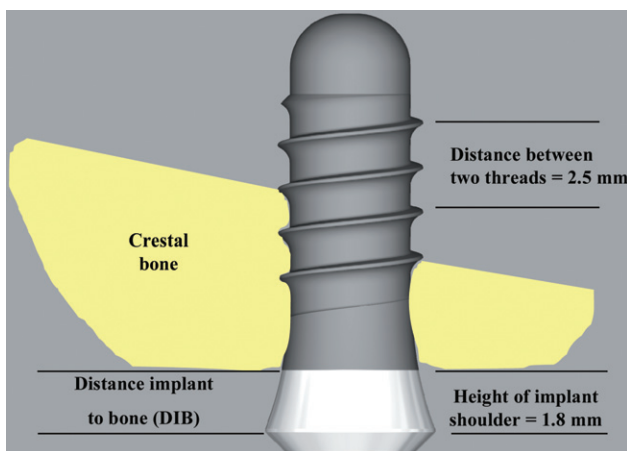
Measurement of radiographic bone level.
